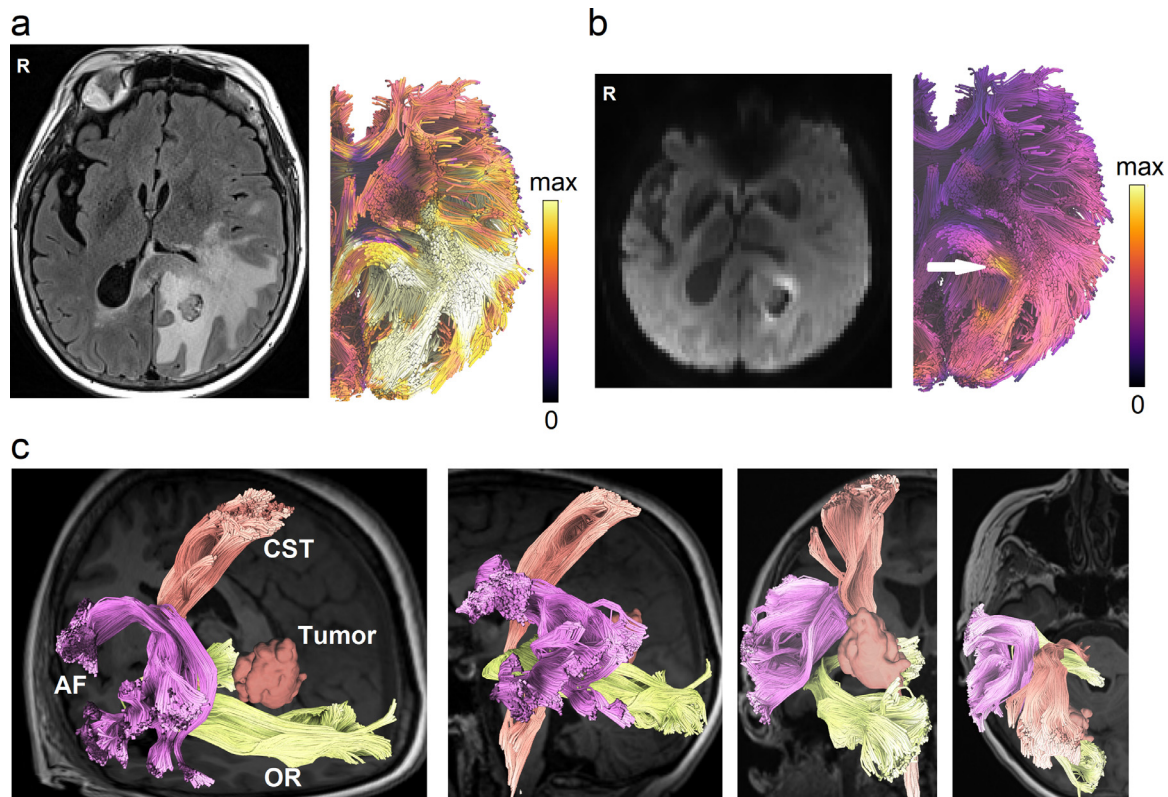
Novel tractography approaches showing perilesional white matter pathways of a 65-year-old female patient with glioblastoma multiforme (GBM) to assist presurgical planning or postsurgical assessment. (a) Advanced tractography can be integrated with other imaging modalities to assist diagnostic and prognostic evaluation. The tractogram is color-coded by T_2 /FLAIR to visualize pathways affected by peritumoral edema. (b) Tractograms can be color-coded according to cell densities estimated from restricted diffusion imaging (Yeh et al., 2017) to highlight tracts infiltrated by tumor cells (annotated by the white arrow). The results may inform the extent of surgical resection to achieve better surgical results. (c) Automated tractography maps the arcuate fasciculus (AF), corticospinal tract (CST), and optic radiation (OR) of the patient to facilitate presurgical planning. This new tractography approach uses prior anatomical information from a tractography atlas to identify white matter pathways, eliminate spurious tracks, and cluster tracks into anatomically defined bundles. This process can reduce the tedious manual placement of seed regions and can improve the test-retest reliability of tractography mapping.
